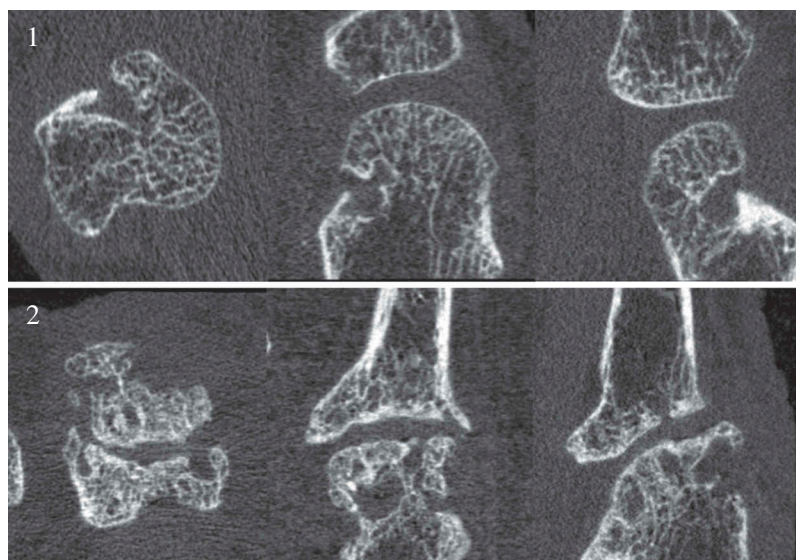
Panel 1: Example of a cortical interruption in axial, coronal, and sagittal view on the radial side of a metacarpal head on high-resolution peripheral quantitative computed tomography (HR-pQCT). Panel 2: Example of an axial, coronal, and sagittal HR-pQCT image of a totally destroyed bone end excluded from further examination.
